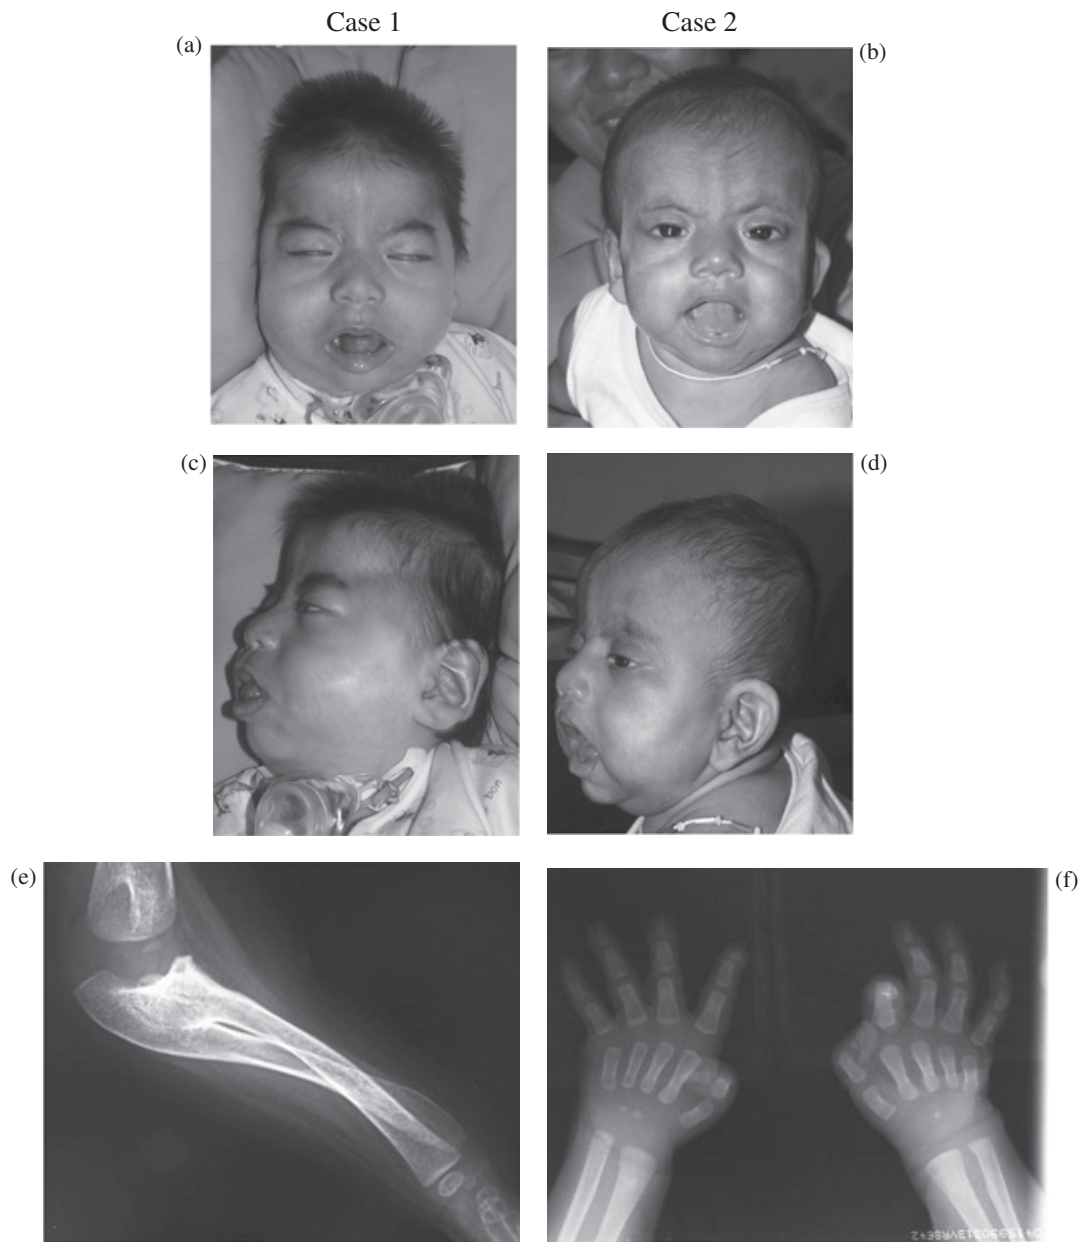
Clinical and radiographical features. The left panel for Case 1 (a, c, e) and right panel for Case 2 (b, d, f). Faces anteriorly (a and b) show prominent forehead, bitemporal narrowing, shallow orbits, midface retraction and a protruding tongue. Faces laterally (c and d) show prominent ear lobes. Radiograph of the left elbow of Case 1 shows radioulnar synostosis (e) and that of hands of Case 2 shows short first metacarpals and hypoplastic distal phalanges bilaterally (f).
